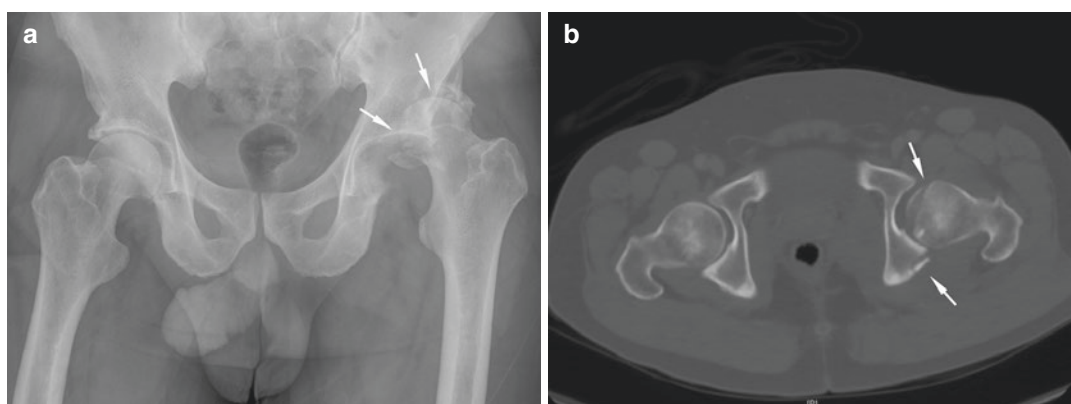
The conventional ap radiograph shows a Pipkin IV fracture left with concomitant posterior hip dislocation (a). The CT scan after closed reduction shows fragment
